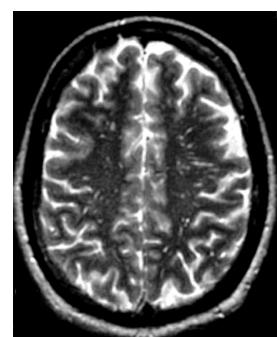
Contrast-enhanced T2-weighted axial image shows diffuse thickening and enhancement of dura mater.
